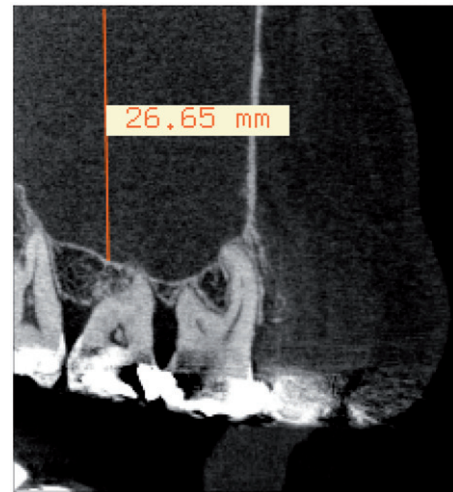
CBCT image showing a sinusitis case.
